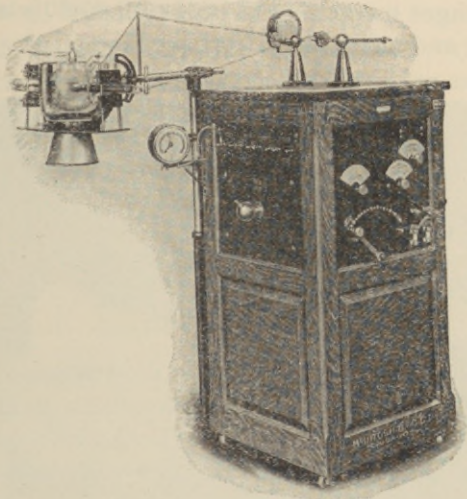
The Hogan 2 K. W. Combination of X-Ray Unit and High-Frequency. This apparatus is somewhat unique, as it affords all of the advantages of a modern Bedside Unit, capable of operating a 30 M. A. Radiator Type Coolidge Tube to full capacity, or a Self-Rectifying Gas Tube, with built-in Coolidge Control with filament transformer in the same tank with the high-tension winding, together with a complete high-frequency resonator operable from the same high-tension transformer which is employed for X-Ray work.
